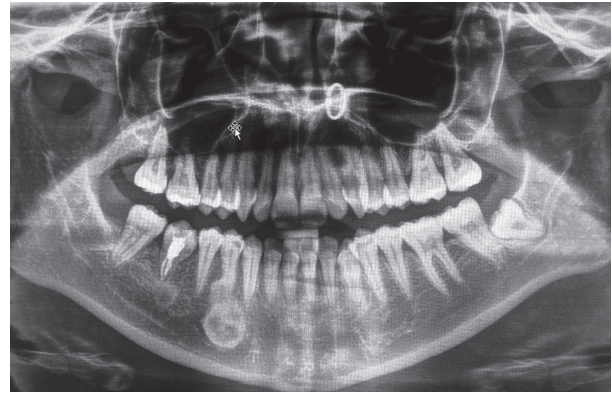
Panoramic radiograph of the patient after endodontic treatment
